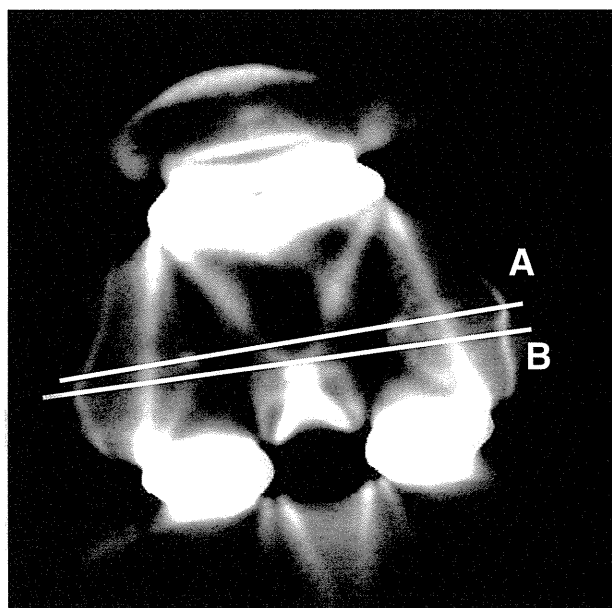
Evaluation of rotational alignment of components on CT images. The rotational femoral component angle is defined as the angle between lines A and B. (A: Line through the center of both fixation pegs. B: Surgical epicondylar line).
